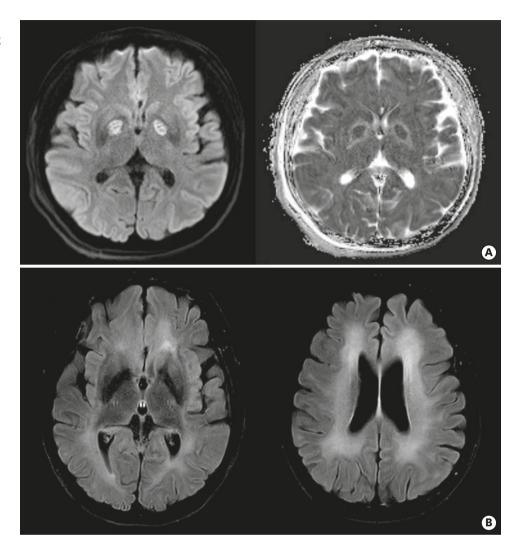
Bilateral globus pallidi in diffusion weighted image with apparent diffusion coefficient alterations on initial magnetic resonance imaging (A) and bilateral both periventricular and subcortical white matter changes on follow-up fluid-attenuated inversion recovery image (B).
